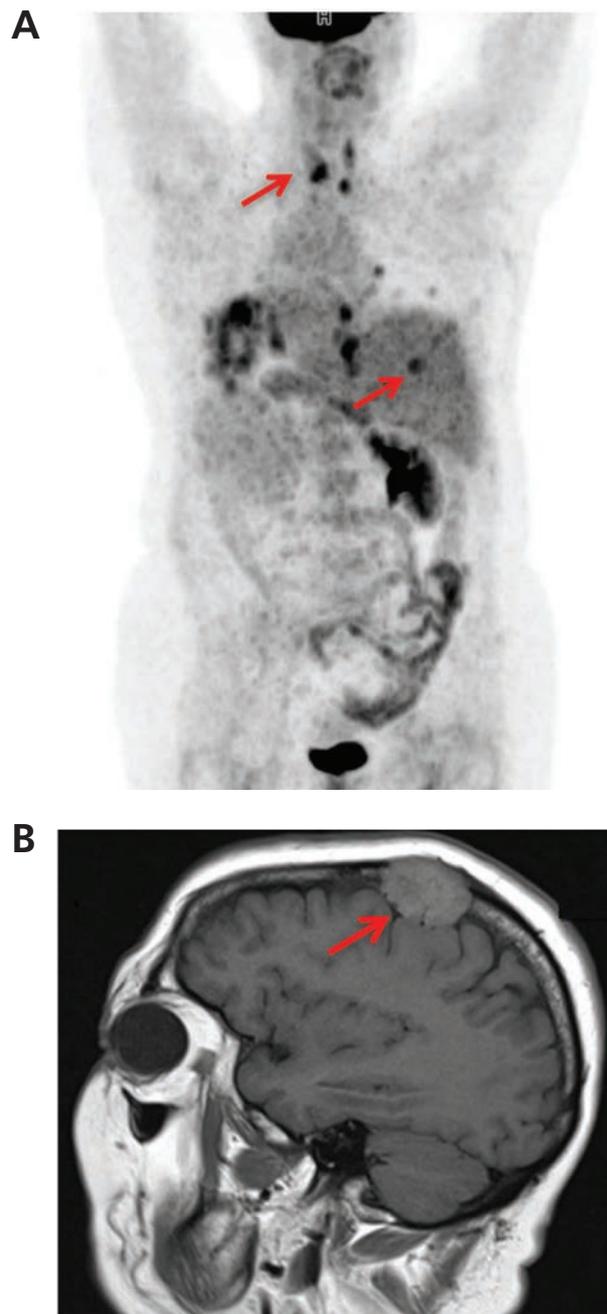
(A) Initial tumor dissemination detected by PET/CT (arrows). (B) MRI showing skull metastasis (arrow), which was surgically removed in 2015.
